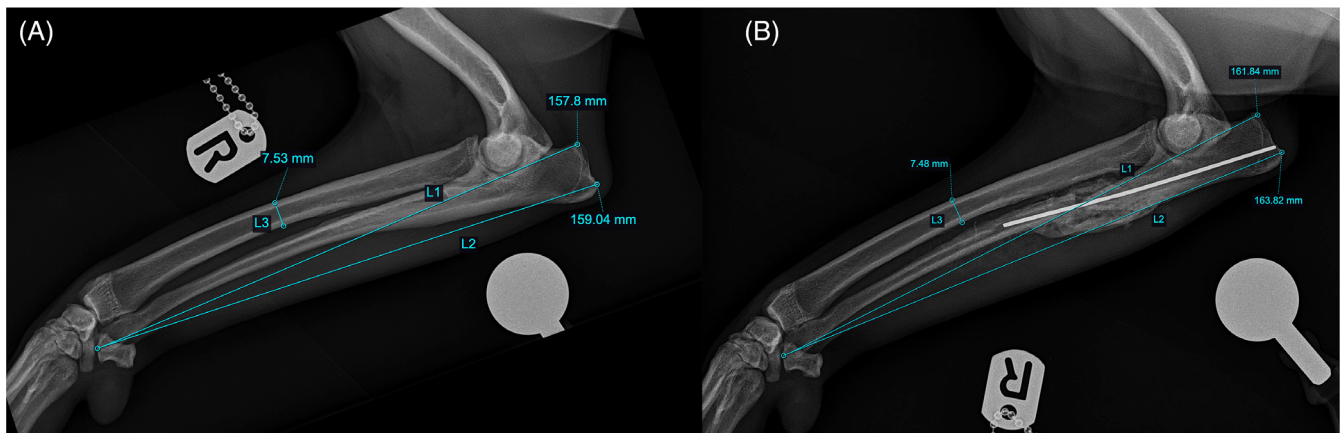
Radiographic measurements performed on the medio-lateral view of the affected antebrachium, prior to surgery (A) and at the time of 6-week follow-up radiographs (B). The first line (L1) was drawn and measured from a point at the most cranial aspect of the dorsal cortex of the olecranon to an easily recognizable point at the distal end of the styloid process of the ulna. A second line (L2) was then drawn and measured from an easily recognizable point (such as where the k-wire was engaging the cortex for example) at the caudal aspect of the dorsal cortex of the olecranon to exactly the same point at the distal end of the styloid process of the ulna where the first line ended.
